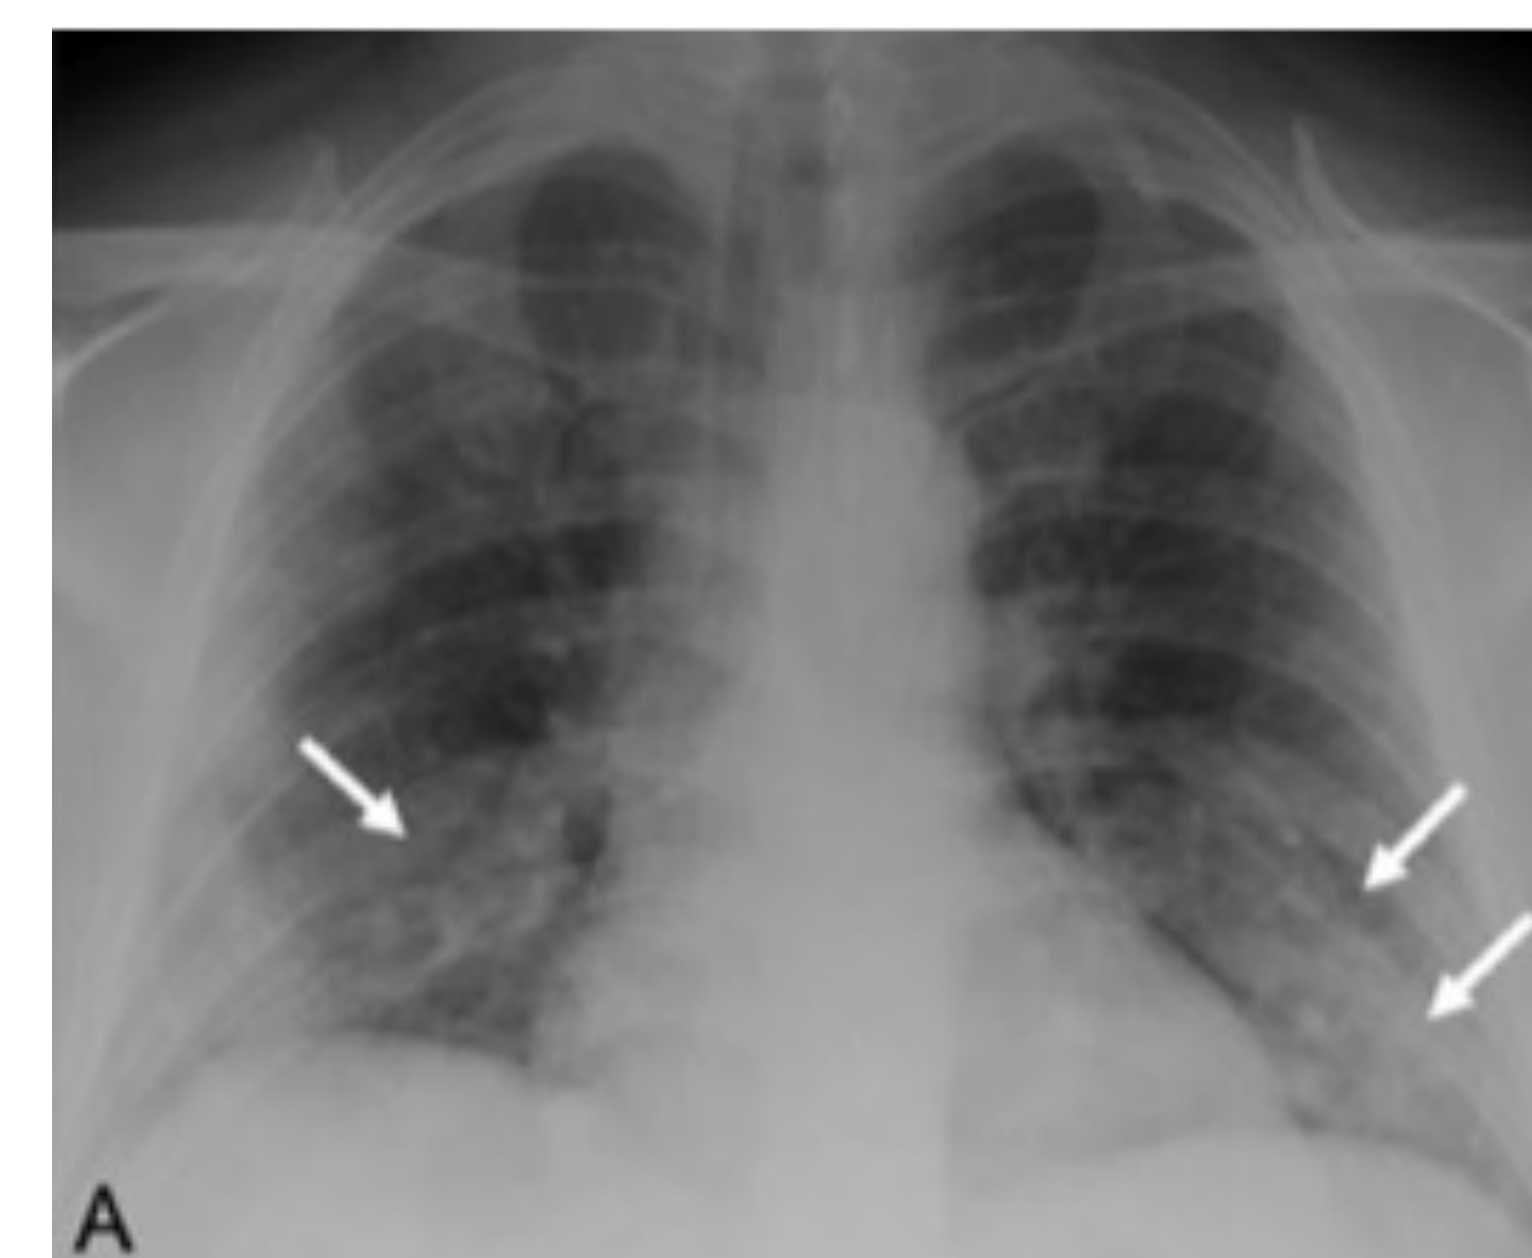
Chest x-ray on day 1 of COVID-19 diagnosis with arrows pointing to opacities seen bilaterally in the lower lobes (Bhat et al., 2020, p. 299).
